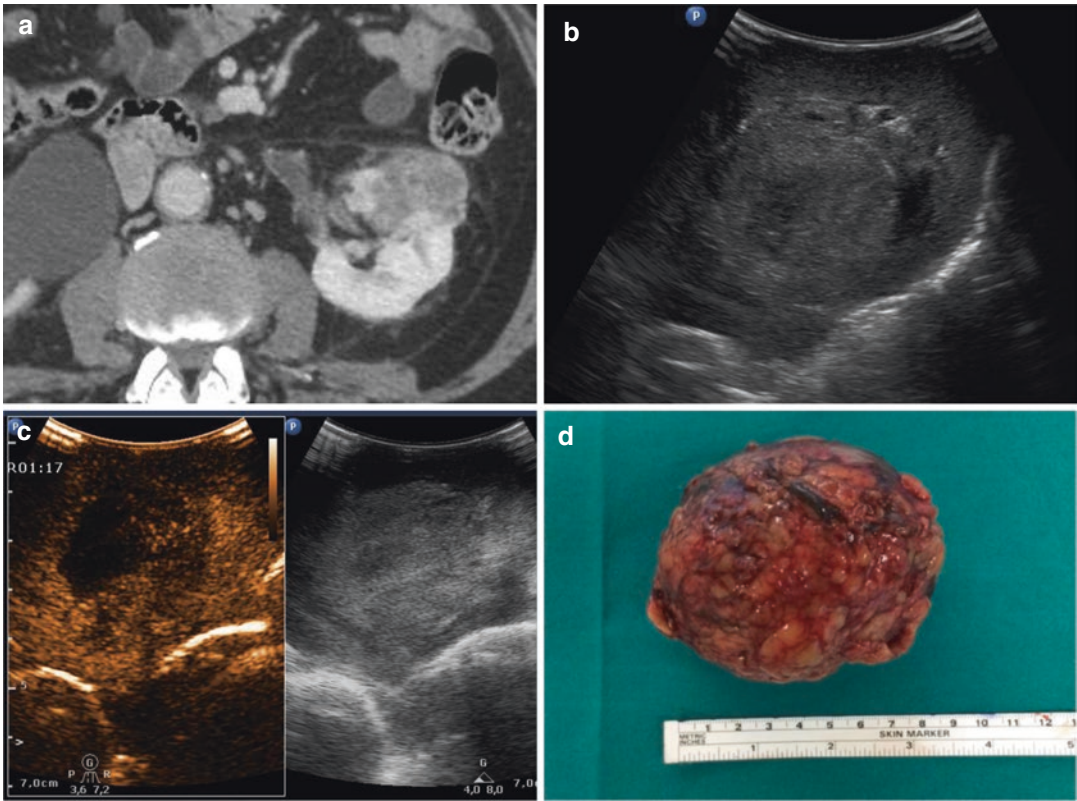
(a–d) A 68-year-old male patient with massive primitive endophytic lesion (8 cm in diameter) at the middle third of the left kidney. Axial CT investigation (a) with evidence of a solid endophytic lesion with heterogeneously hypo-vascularization that comes to affect pyelic region without apparent infiltration on vascular
